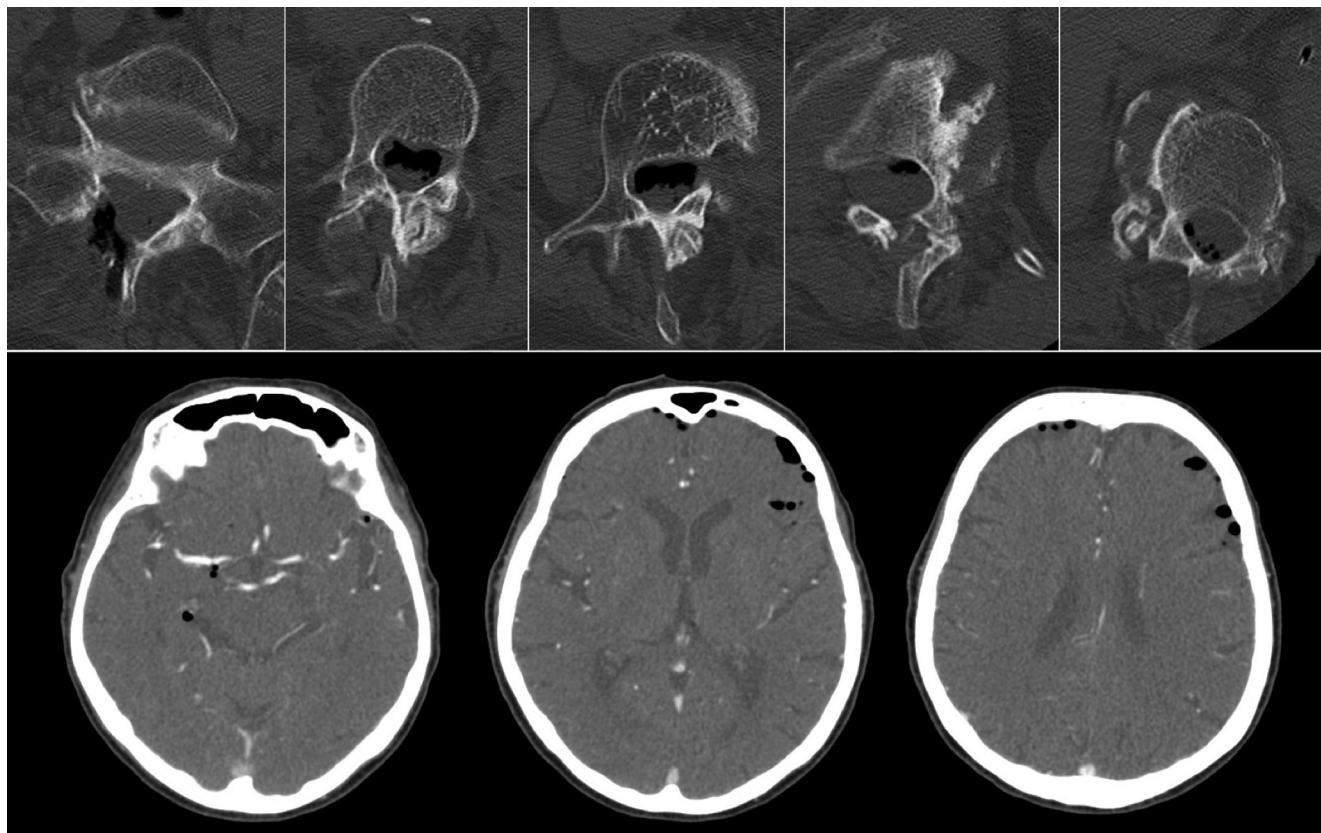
(Top) Computed tomography (CT) images of the thoracic and lumbar spine show epi- and intradural air trapped in the operated lumbar segment ascending cranially up to the upper thoracic spine. (Bottom) The subdural air entrapment in the posterior cranial fossa and supratentorial, reaching up to the frontal region, can be seen on these CT-angiography images as well. No vascular abnormalities were observed.
